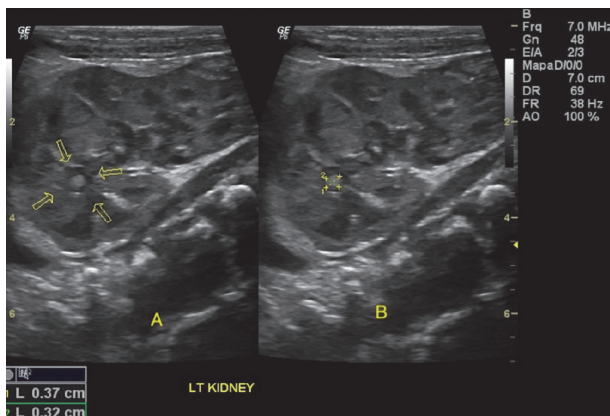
Ultrasonographic assessment of the third patient performed at 17 days of life demonstrating a hyperechogenic oval image suggestive of a fungal ball in the upper calyx group of the right kidney (delimited by the yellow arrows in A and being measured by the calipers in B).
